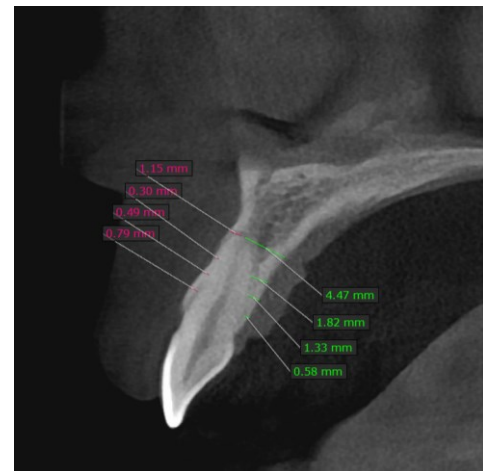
Measuring the thickness of alveolar bone in the marked regions in CBCT
